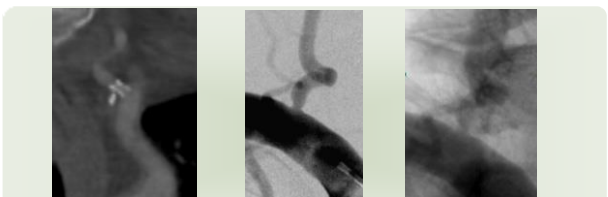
69 year-old patient with a symptomatic left VA orifice stenosis was stented, CT angiography and DSA follow up showed no restenosis.
